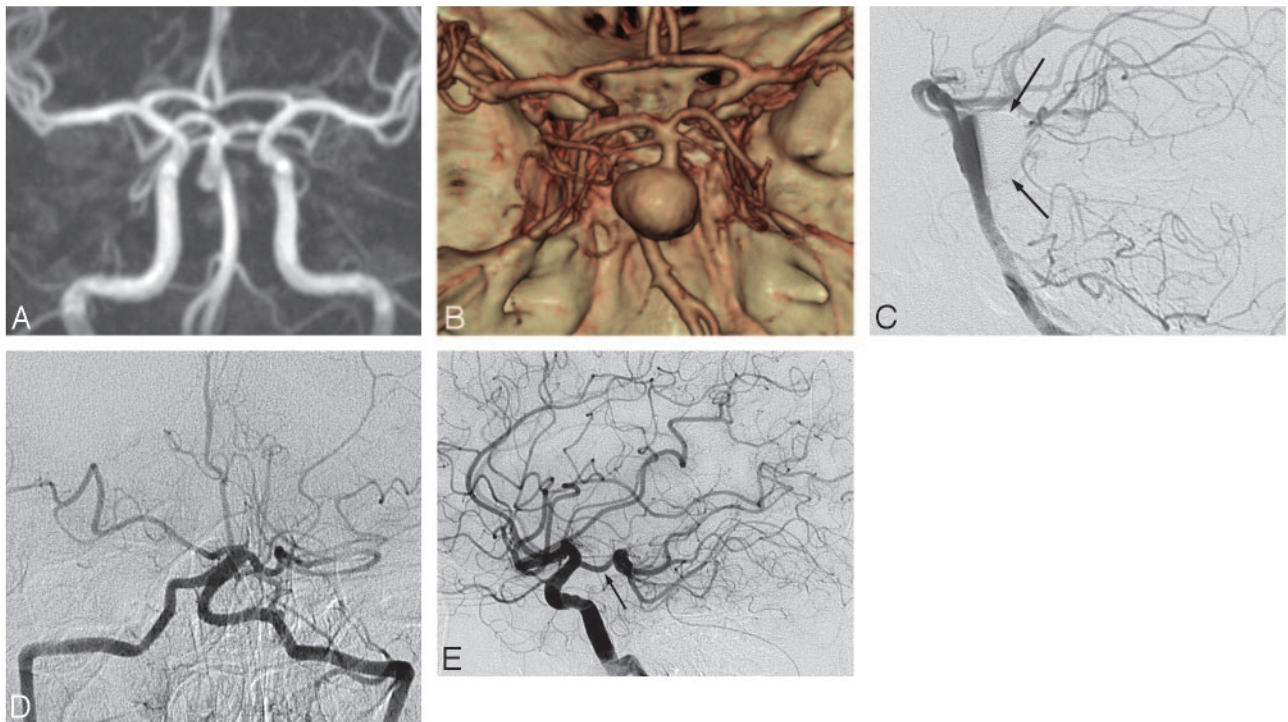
A 30-year-old man presenting with signs of stem compression 3 years after initial presentation of brain stem infarction. A, Initial MR angiogram reveals focal asymmetric dilation in the distal basilar artery. B, CT angiogram 3 years after initial MR imaging as a result of brain stem compression. A large asymmetric pseudoaneurysm is demonstrated in the same location. C, Vertebral angiogram in lateral projection after overlapping double-stent deployment shows flow redirection through the stent and the basilar artery with stasis of contrast media in the pseudoaneurysmal sac (arrows). D and E, A 4-month follow-up vertebral artery angiogram (D) and right internal carotid artery angiogram (E) reveal occlusion of the basilar artery and hypertrophied right posterior communicating artery (arrow), which supplies the distal basilar artery and its branches.
